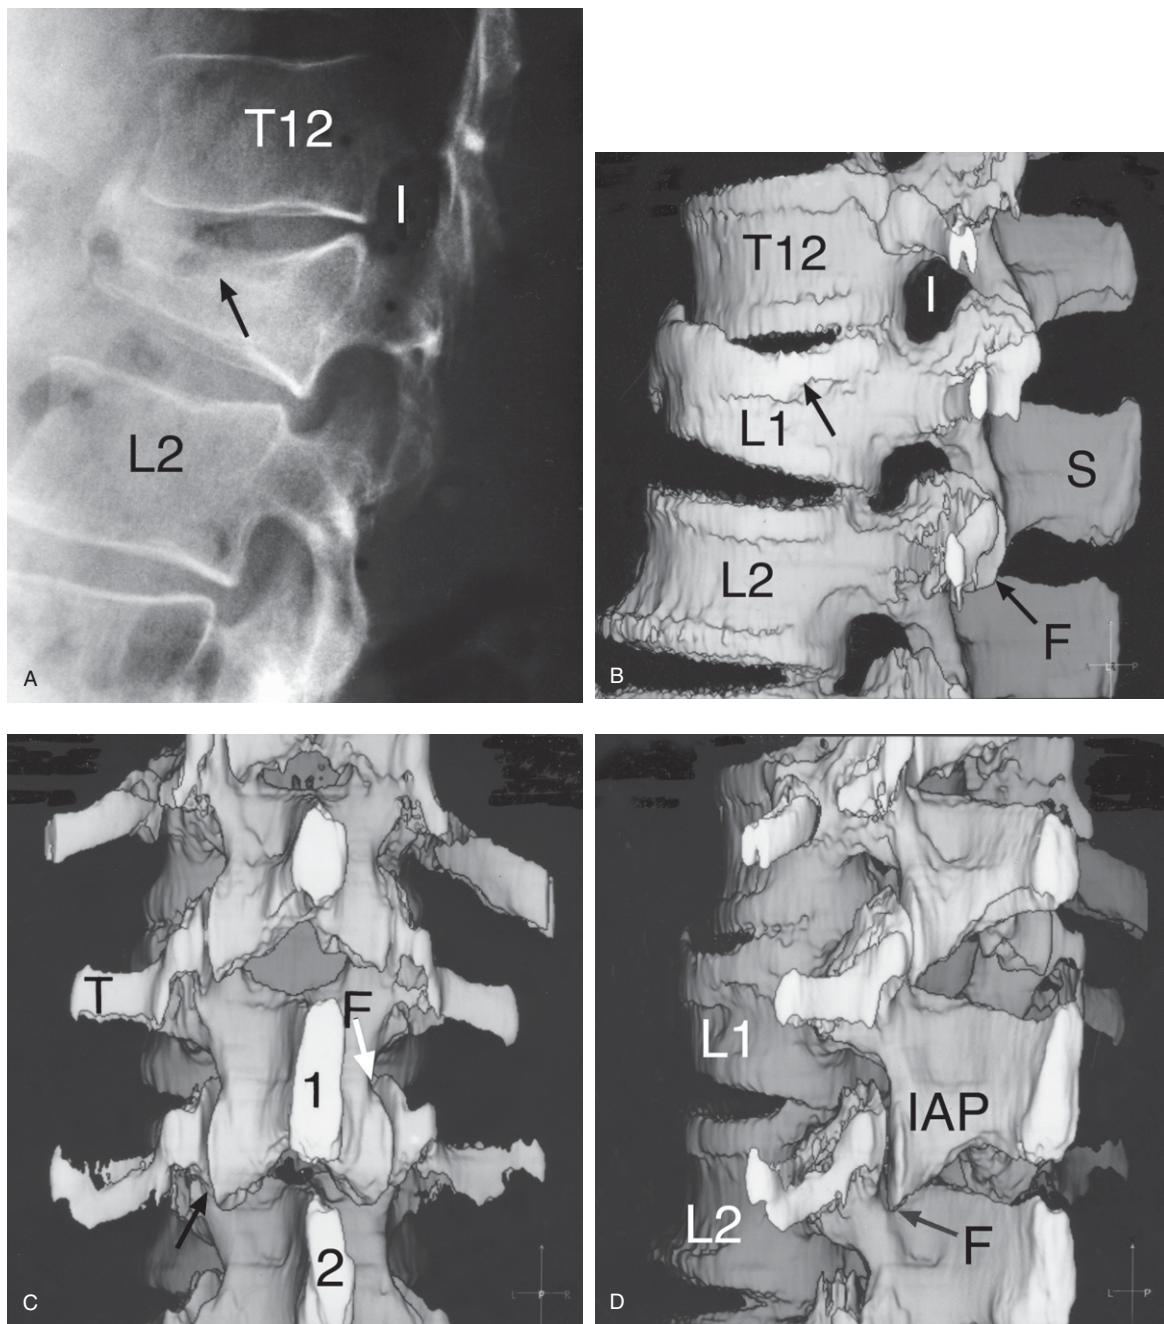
(A) A lateral thoracolumbar spine plain X-ray image showing compression of the superior endplate of the L1 vertebra (arrow), consistent with a fracture. I = intervertebral foramen at the T12–L1 level; L2 = second lumbar vertebra. (B) A CT lateral 3-dimensional reconstruction image. This reconstruction image better shows the T12–L1 disc space with the compression of the superior endplate of the L1 vertebral body (arrow). There is some extension of the L1 vertebra on the L2 vertebra with subluxation/imbrication of the opposing facet surfaces (F) at L1–2. This subluxation is seen to be occurring bilaterally in the reconstruction (C) and is also clearly demonstrated in the oblique projection (D). I = intervertebral foramen; S = spinous process. Note how the intervertebral foramen at the L1–2 level (B) is distorted, when compared to the level above, because of the L1–2 subluxation of the facet surfaces due to the L1 vertebra tipping backwards ('extension') on the vertebra below. (C) CT postero-anterior 3-dimensional reconstruction image. T = transverse process; 1 = spinous process of the first lumbar vertebra; 2 = spinous process of the second lumbar vertebra; F = facet surface and subluxation. (D) CT oblique 3-dimensional reconstruction image. Note how the inferior articular process of the L1 vertebra (IAP) approximates the pars interarticularis area of the L2 vertebra below. F = facet surface and subluxation.
